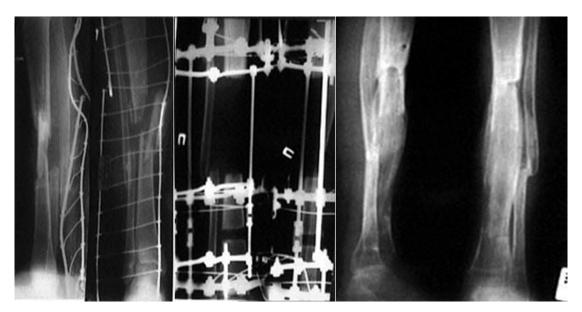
X-rays of the right tibia of a patient with traumatic osteomyelitis
